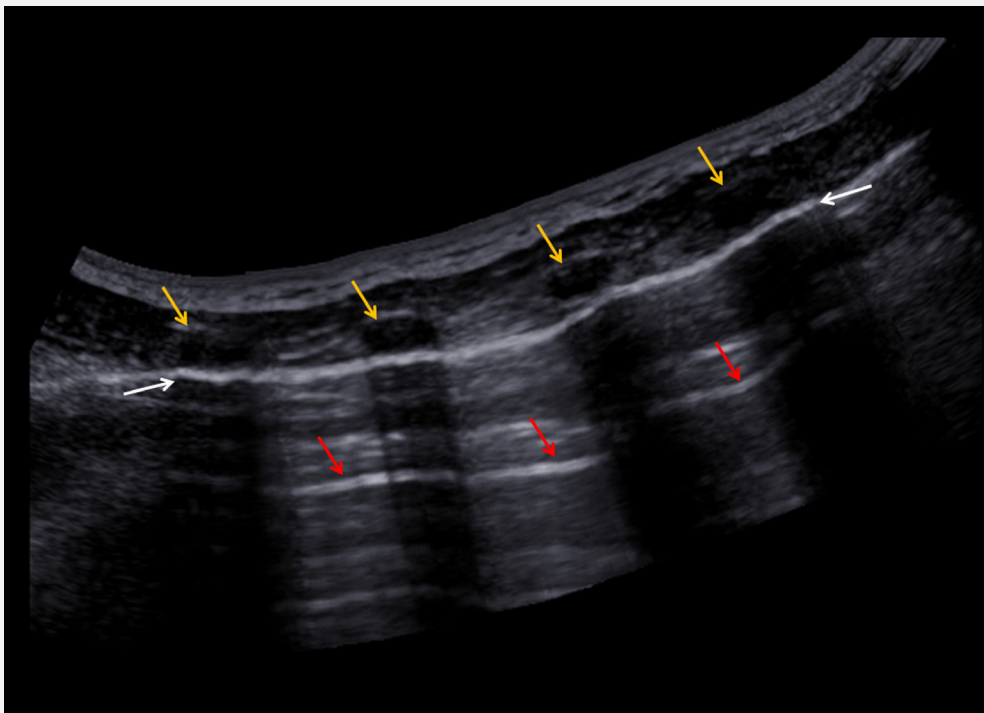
Ultrasound image using the Samsung HM70A.
